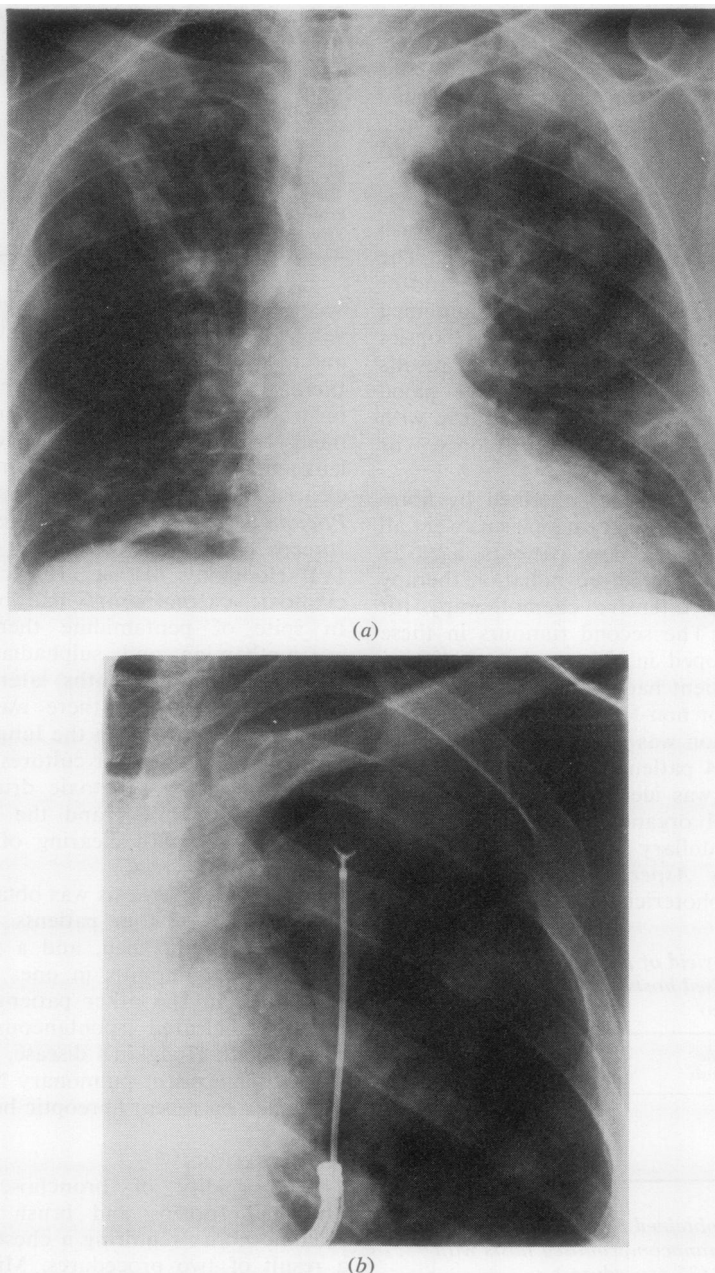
Chest radiograph of a 65-year-old man (RM) with histiocytic medullary reticulosis receiving cytotoxic drugs and prednisone: (a) shows a bilateral, predominantly nodular infiltrate; (b) demonstrates the position of the biopsy forceps in the left upper lung zone during fiberoptic bronchoscopy. *Aspergillus fumigatus* was isolated on both transbronchial brush and forceps biopsies. *Aspergillus precipitans* rose from a titre of 1:8 to 1:32.
